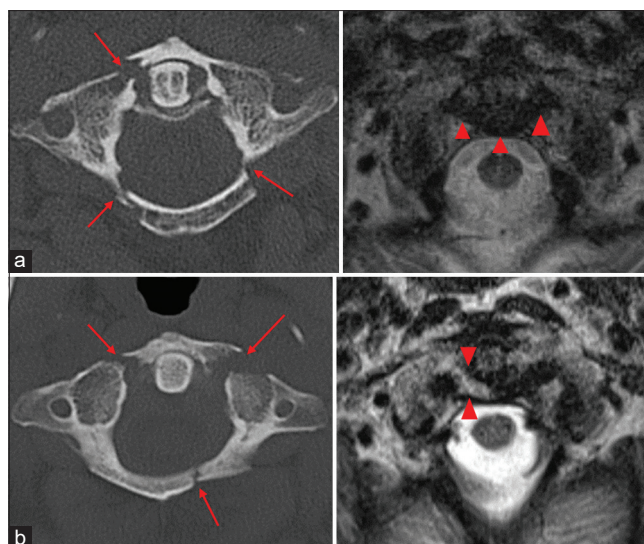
(a) Axial CT of the cervical spine (left) in a 72 year old trauma patient status post MVA demonstrating a right C1 anterior arch fracture and bilateral C1 posterior arch fractures (red arrows). Note is made of a mineralized transverse atlantal ligament (red arrowheads). Axial T2 weighted MRI (right) in the same patient demonstrates an intact transverse atlantal ligament (red arrows). (b) Axial CT of the cervical spine (left) in a 54 year old trauma patient status post MVA demonstrating bilateral C1 anterior arch fracture and left C1 posterior arch fractures (red arrows). Axial T2 weighted MRI (right) in the same patient demonstrating a torn right transverse atlantal ligament (red arrowheads). CT - Computed tomography, MRI - Magnetic resonance imaging, MVA - Motor vehicle accident
